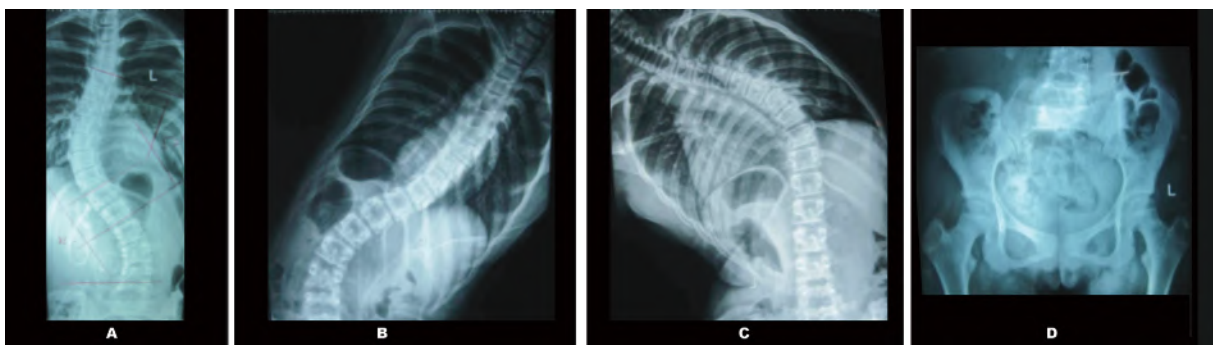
Pre surgery standard scoliosis plain radiographic examination
